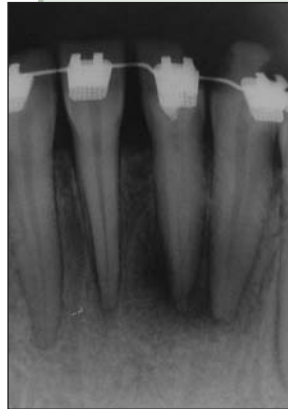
The periapical radiolucency decreased after the $\text{Ca}(\text{OH})_2$ dressing was left in the root canal for 12 weeks.
